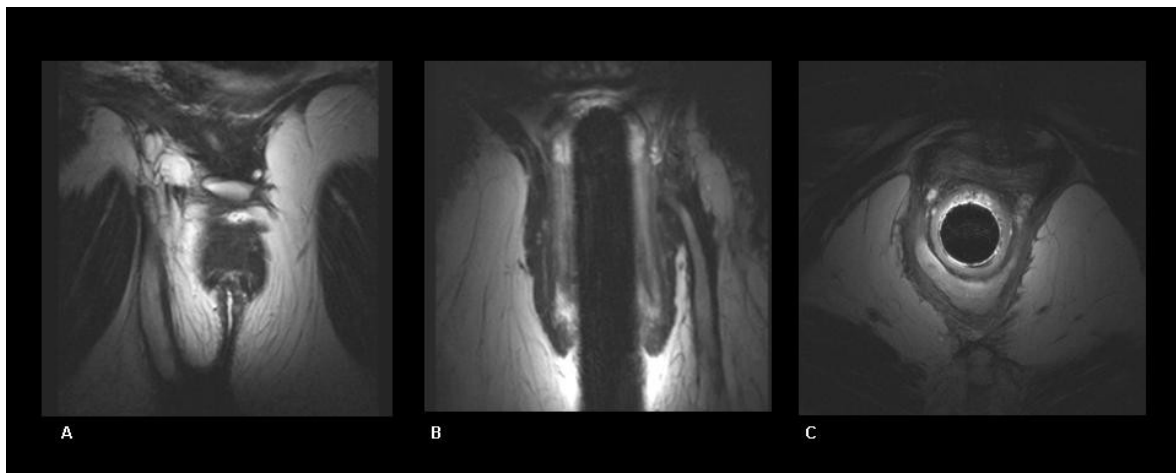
MR imaging with an endoanal
